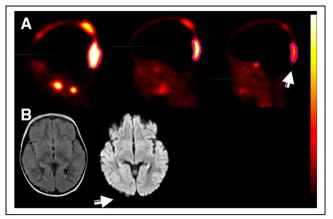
(A) Improved but persistent bony skull lesions (arrow) at, from left to right, initial staging, 2 mo, and 6 mo on ⁶⁸Ga-DOTA-TATE PET. (B) These changes (arrow) are not well visualized, however, on correlative T1-weighted and fluid-attenuated inversion recovery MRI performed on same day at 6 mo.
